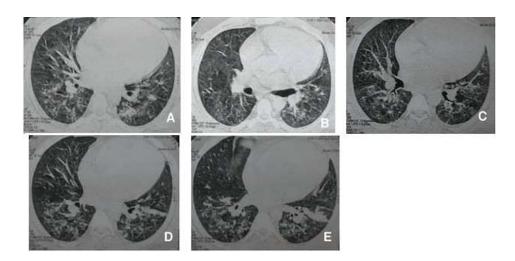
a lung high resolution computed tomography (HRCT) (A, B, C, D, E): showing inflammatory infiltrates in the both lung, nodules in the lower lobe of the right lung, alveolar condensation with air bronchogram in the left pulmonary base and subsegmental atelectasia in the right middle lobe
